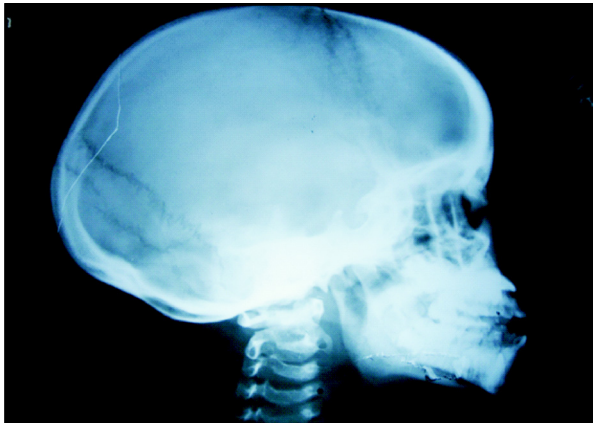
5, x-ray skull lateral view showing incomplete closure of anterior fontanelle, prominent pituitary fossa and delayed dentition with unerupted permanent teeth .
